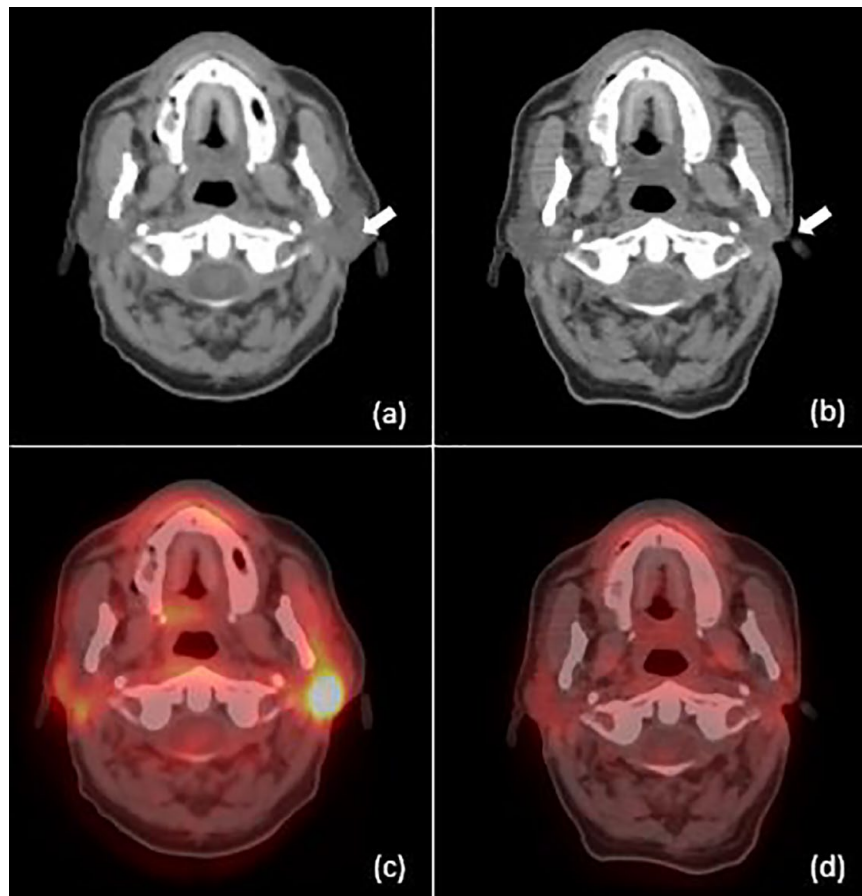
Pre and postoperative positron emission tomography (PET), showing the evolution of left parotid hypermetabolism. (a) Preoperative CT axial section. (b) Postoperative CT axial section. (c) Pre-operative PET-CT image. (d) Post-operative PET-CT image. [white arrow=left parotid mass].
